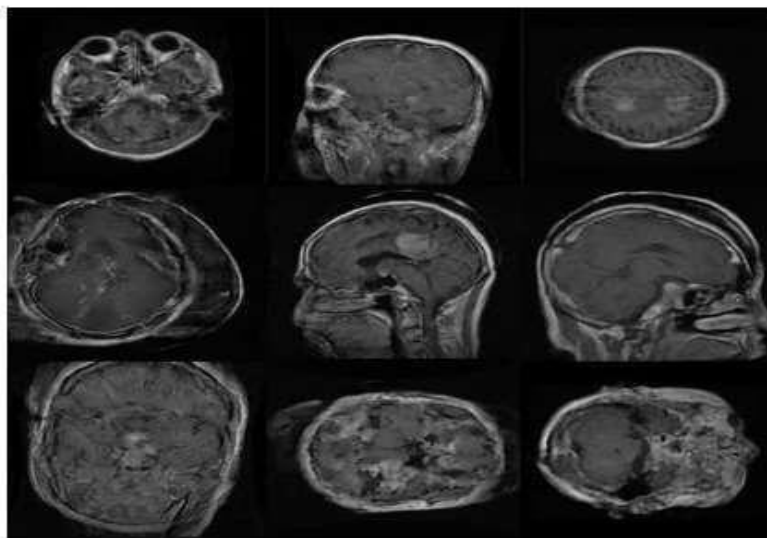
Samples of „wrong“ synthetic MR images produced by PGGAN.
